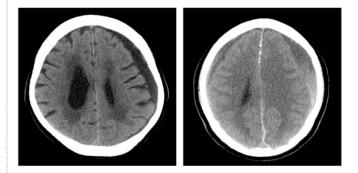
Axial CT scan demonstrates a left sided chronic subdural haematoma, note the sulcal gyral pattern is maintained, not suggestive of significant mass effect. Fig b demonstrates bilateral chronic subdural haematomas, greater in size on the left. These collections are sub-acute, hence the mixed density and are exerting more pressure as indicated by the loss of sulcal-gyral pattern
